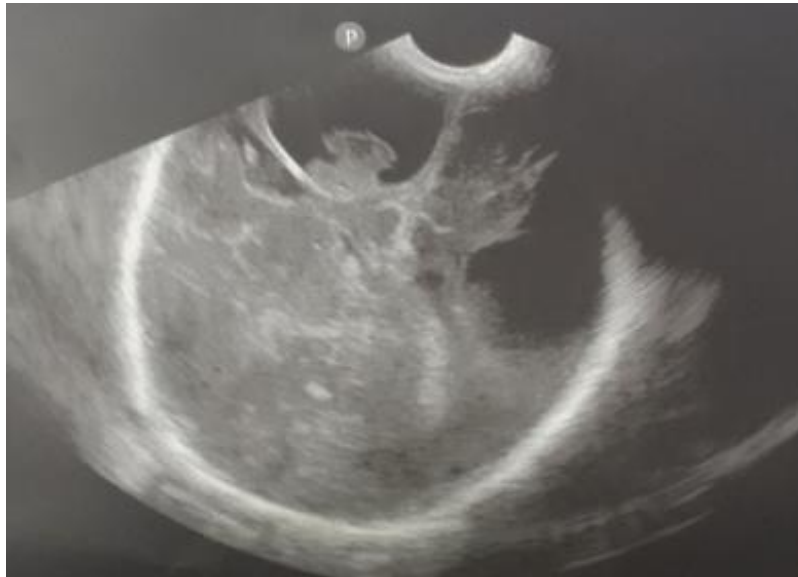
Cranial ultrasound demonstrated a few well defined anechoic cystic lesions in both cerebral hemispheres with isoechoic nodules inside.
